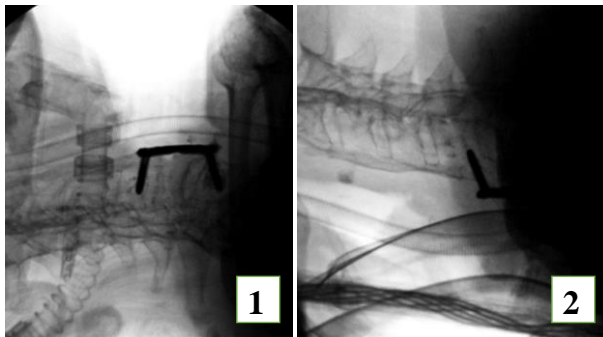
B. 1. Intraoperative radiography after fixation with anterior plate with cemented screws. 2. Radiograph after ventral positioning with pull out of the C5 body screws.
